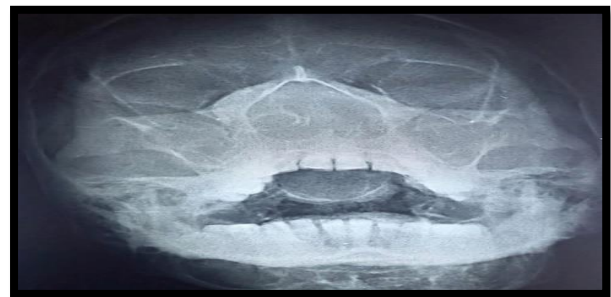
Showing the X-ray PNS (Waters' view) that is delineating the complete obstruction of nasal cavity and maxillary sinuses with Sino-nasal sarcoma
